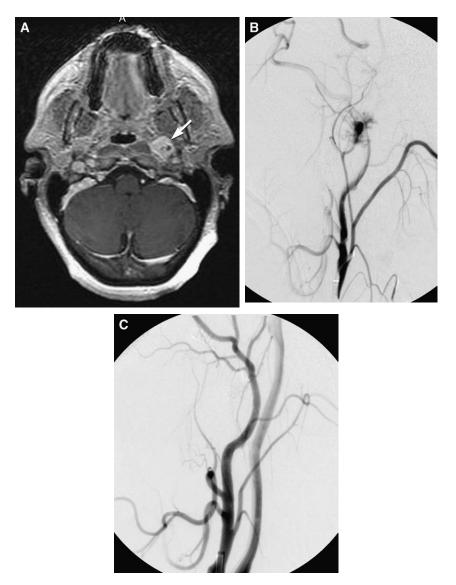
(A) Axial postcontrast MRI shows an enhancing tumor consistent with a glomus vagale in the left carotid sheath (arrow). (B) The predominant blood supply is from a branch of the ascending pharyngeal artery. (C) No residual supply to the tumor is seen after glue embolization.
